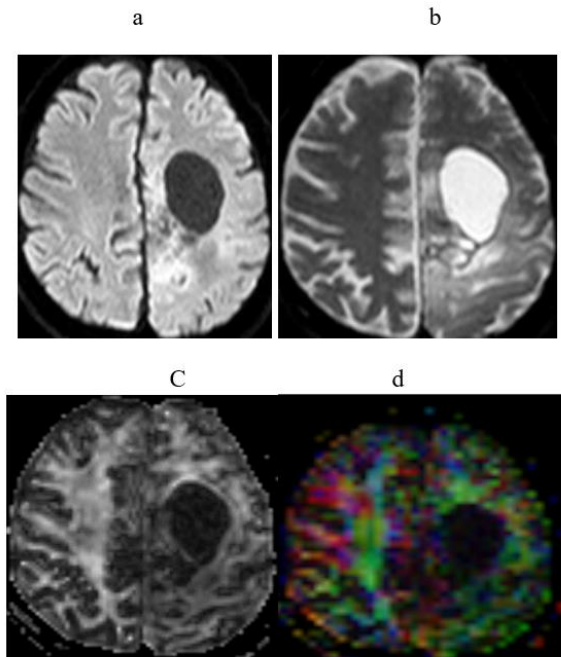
a) Axial DWI demonstrating facilitated diffusion. b) Axial ADC maps demonstrating high signal of lesion. c) Axial FA map demonstrating low signal of lesion. d) axial FA color demonstrating color disorganization.
